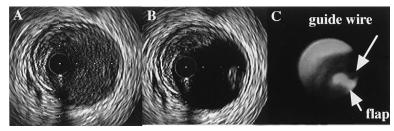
Intravascular ultrasound cross-sectional images and a coronary angioscopic picture of a representative case after directional coronary atherectomy. A, a plain ultrasound image showed a wide lumen with a small amount of residual plaque; B, a negative contrast image revealed a bulky flap at 3 to 4 o'clock, which was wavering. The border between the lumen and the plaque was also clearly demonstrated; C, coronary angioscopy comfirmed this flap.
